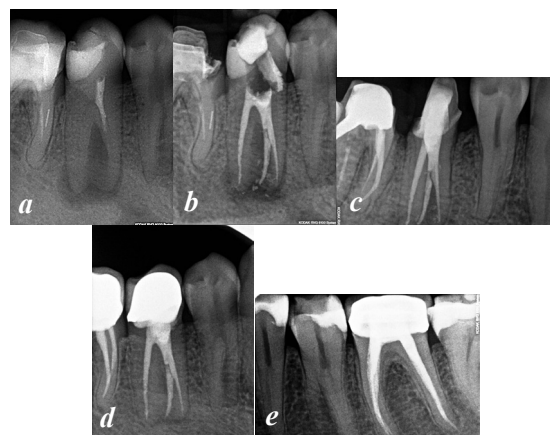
Second case of retreatment of #45: (a) preoperative, (b) final, (c) 6 months control, (d) 66 months control and (e) controlateral radiographs. Healing of the periapical lesion after the endodontic retreatment of the tooth. The controlateral second premolar appears the anatomic abnormality, also
